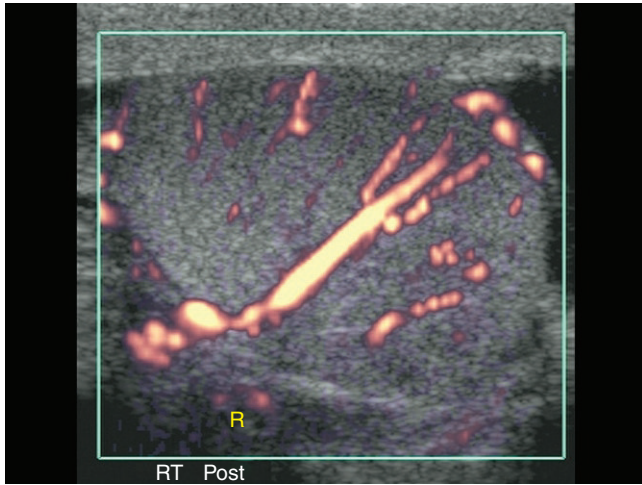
Approximately three minutes after obtaining the image in Figure S71-2, there is testicular flow. The patient had manual detorsion of the testis, and the second power Doppler image was obtained showing a return of color flow in the right (R) testis.
